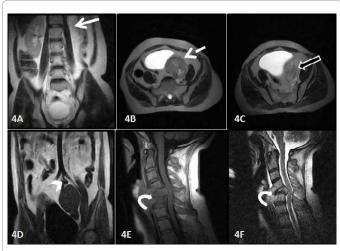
Magnetic resonance imaging confirming the findings with empty left renal fossa (white arrow), mass in ectopic left kidney (dotted arrow), normally visualized parenchyma of left kidney(black arrow with white outline), ectopic kidney supplied by left common iliac artery and vertebral metastasis in C5 vertebral body with cord compression.
